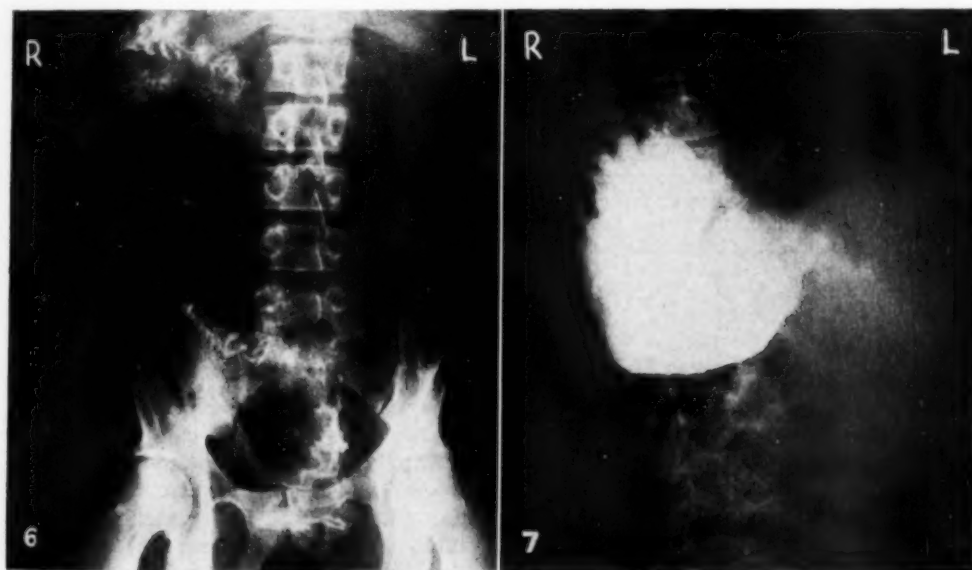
Postoperative post-evacuation roentgenogram showing situs inversus of the large bowel with the cecum in the left lower quadrant, where it had been fixed by the surgeon.
